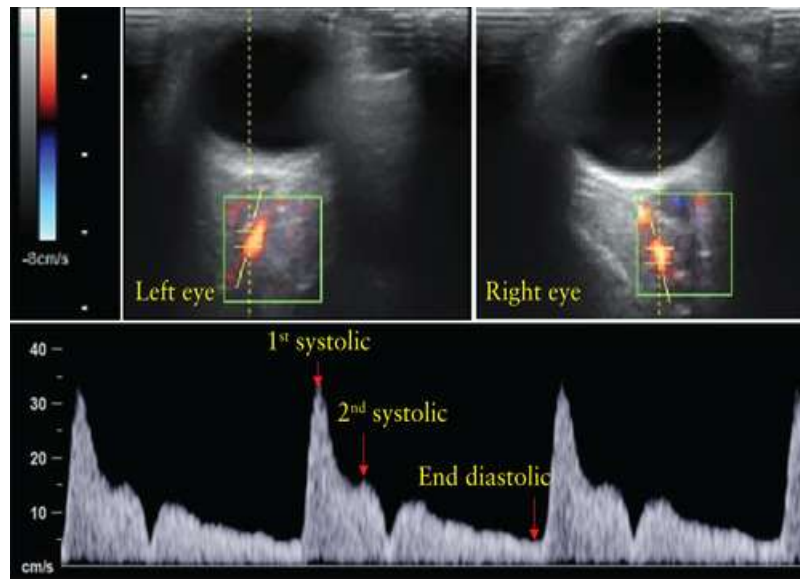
Maternal ophthalmic artery Doppler assessment.
